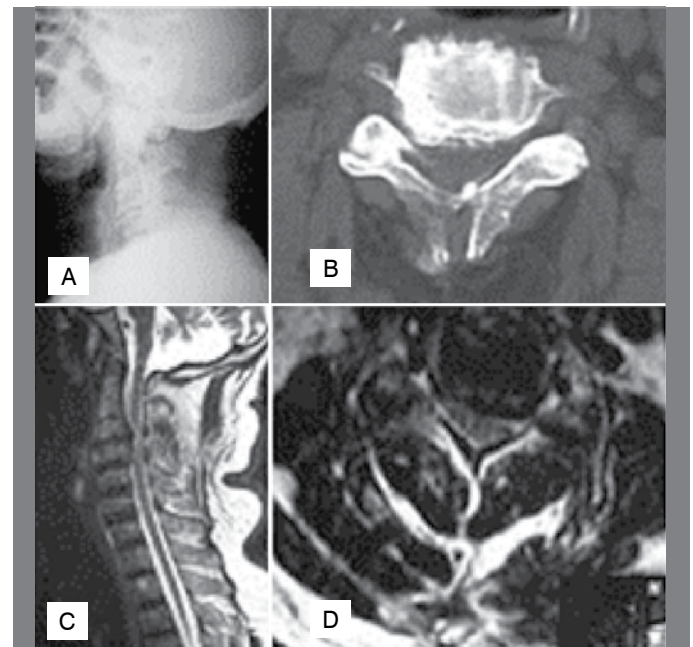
Patient aged 66, driver wearing safety belt with side impact. (A) Radiography showing cervical spondyloarthrosis; (B) axial sections with facet joint impairment and central osteophyte; (C and D) MRI scan showing spinal cord edema. Quadriplegic upon admission, with good response to corticoids.
